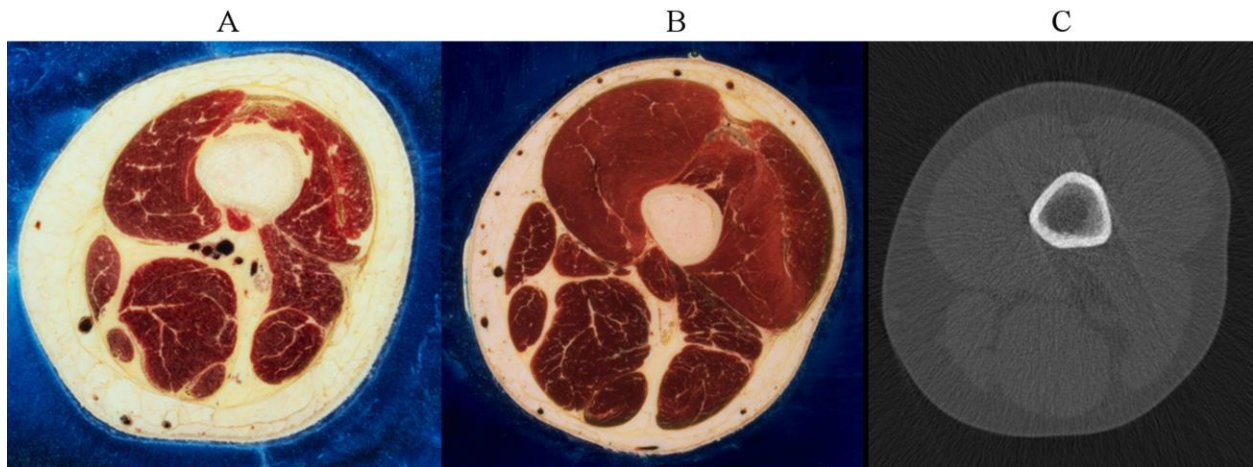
Pane A; image number 4435 of the visible female project 70mm cryosection images, which is approximately three quarters along the length from the femoral neck to the knee joint. Pane B; image number 2203 of the visible man project 70mm cryosection images, which is approximately three quarters along the length from the femoral neck to the knee joint. Note the conspicuous colour difference between intermuscular and subcutaneous fat, and the connective tissue sheet separating the compartments from each other. Pane C; a sample peripheral quantitative computed tomography scan from a similar scan site. Note how the connective tissues are indistinguishable from fat and that no apparent difference can be seen between intermuscular and subcutaneous fat tissues.
